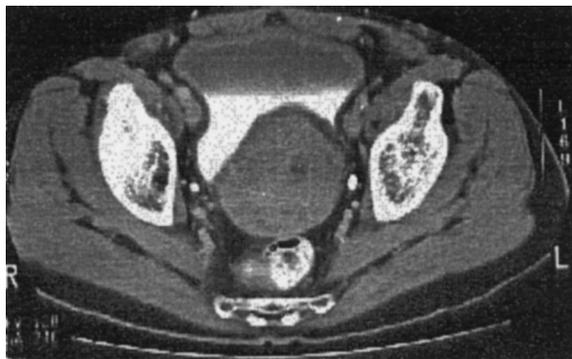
CT of pelvis reveals $7 \times 7 \times 7$ cm. solid mass behind bladder
